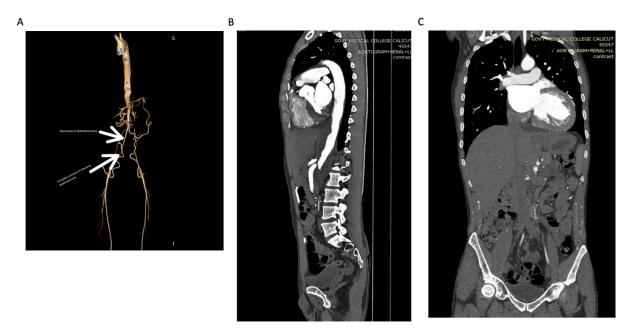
A. CT Aortogram showing narrowing of abdominal aorta and complete occlusion of infrarenal abdominal aorta (white arrows). Aortogram with renal and lower limb contrast showing B. Sagittal view of abdominal aorta occlusion and C. Coronal view of renal occlusion.
